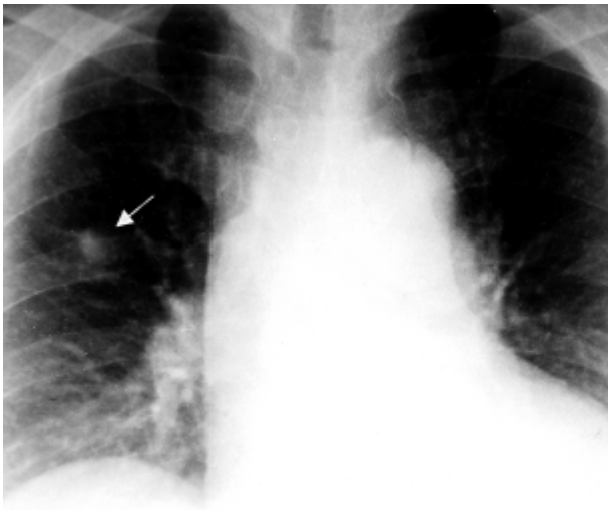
Chest radiograph. Note a 1.5 cm-sized solitary pulmonary nodule in the right upper lobe (arrow). The lung parenchyma is otherwise unremarkable.
